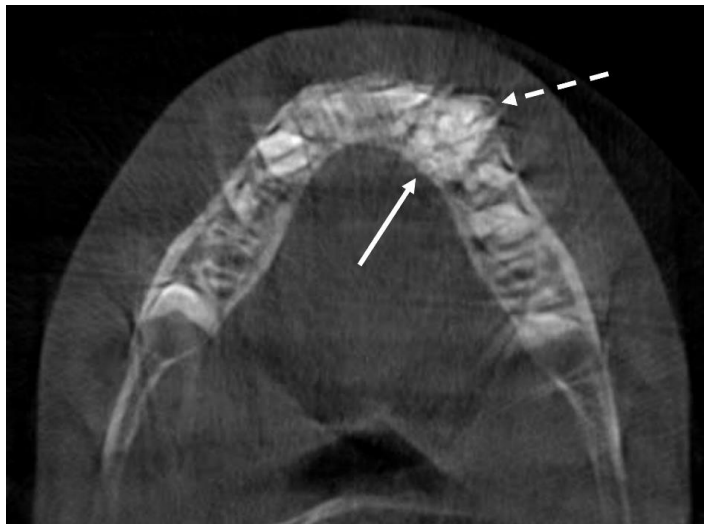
Cone beam computed tomography of the mandible. White arrow: compound odontoma. Dashed arrow: vestibular expansion of the lesion. The image is of lower quality due to movement artifact.
